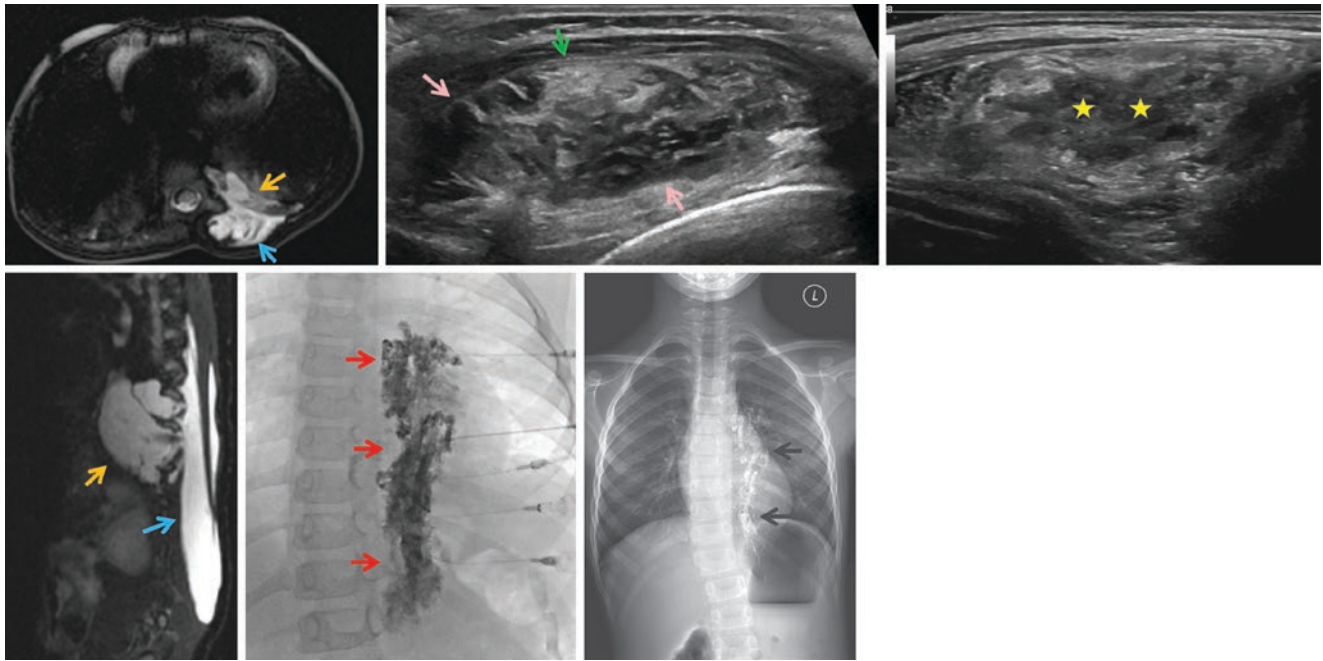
A 6-year-old male with a history of right paraspinal intramuscular venous malformation (blue arrows) with pleural involvement (orange arrows). Ultrasound after one sclerotherapy treatment with STS (sodium tetradecyl sulfate) foam demonstrates partial closure of the superficial portion of the malformation (green arrow) and significant residual open channels (pink arrows) with multiple open channels. Glue
